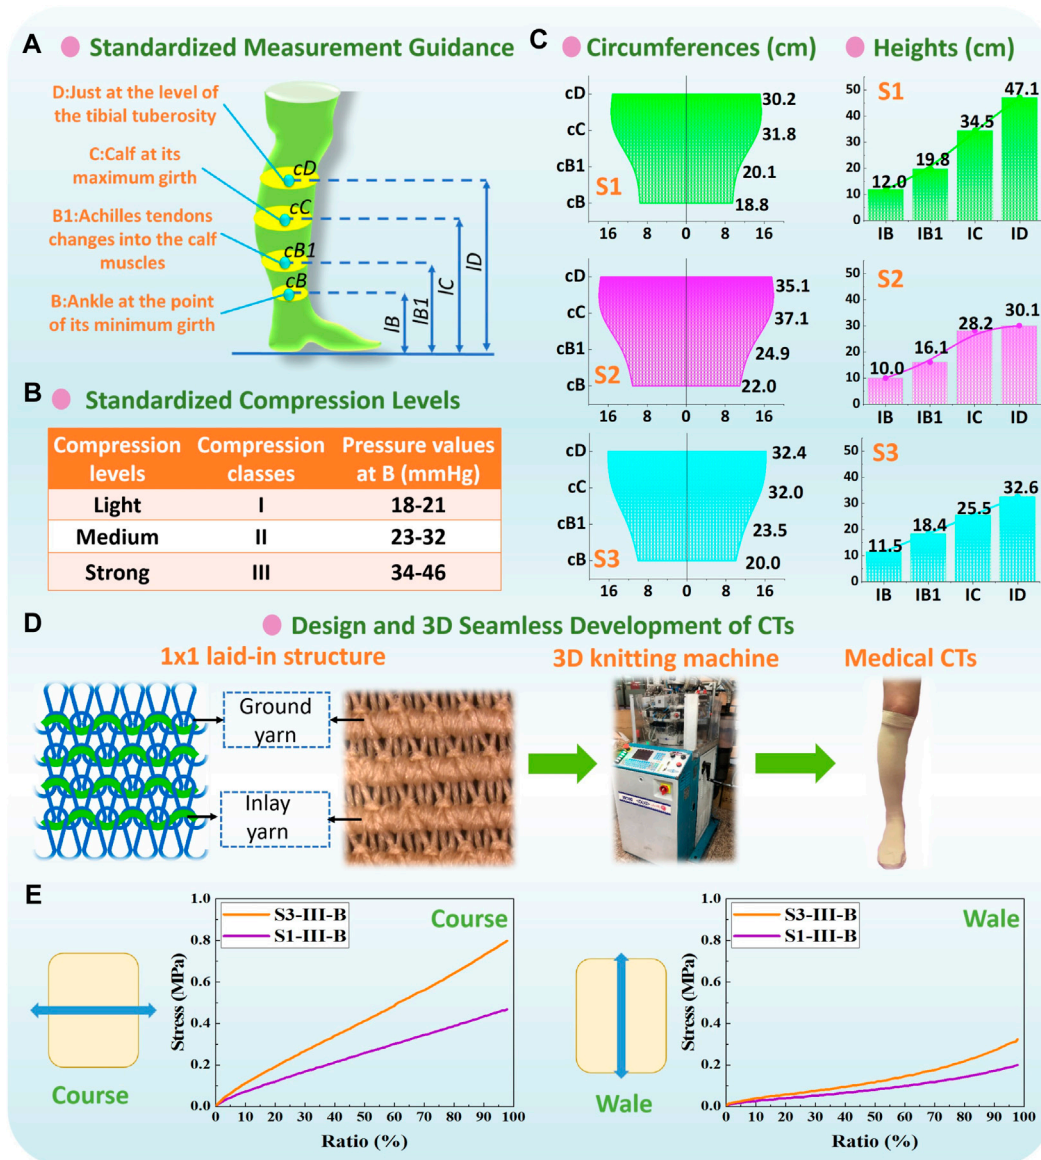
(A) Measurement guidance and (B) compression classification by Germany RAL-GZ 387 standard. (C) Circumferences and heights of each recruited subject legs, and (D) applied 1 × 1 laid-in knitting loop pattern and 3D seamless knitting fabrication. (E) Typical stress–strain curves of CT samples from stretching tests.
